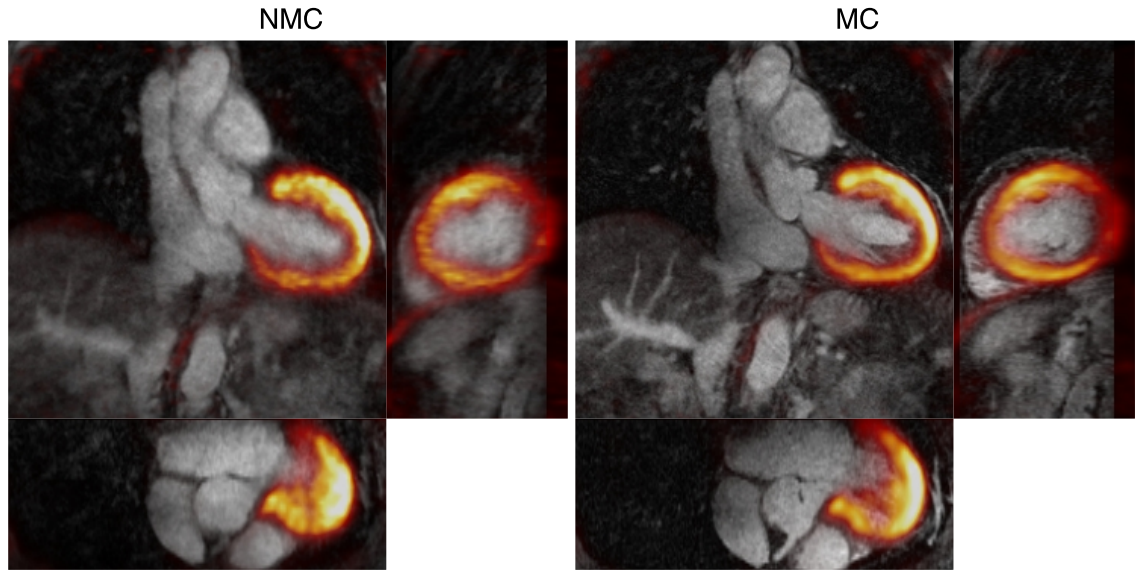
Example fused PET-CMRA image (Patient 4) showing uncorrected (NMC) and motion-corrected (MC) images. The motion correction framework produces co-registered diagnostic PET and MR images where an improved correspondence between both modalities can be observed.
